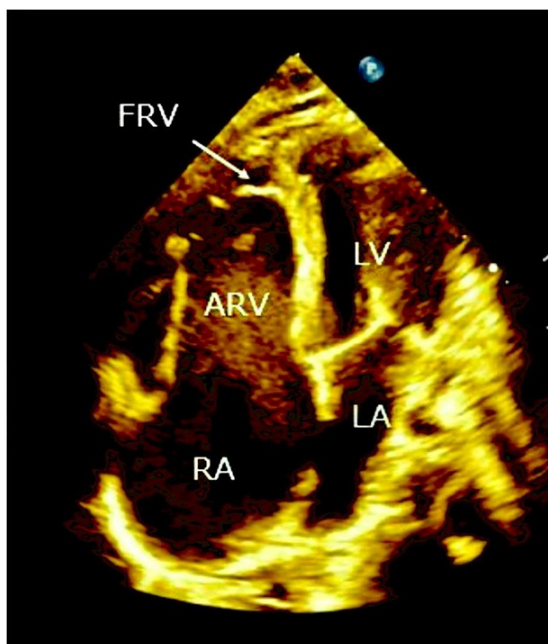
Transthoracic echocardiography apical four chamber view. RA, right atrium; LA, left atrium; ARV, atrialised right ventricle; FRV, functional right ventricle.
